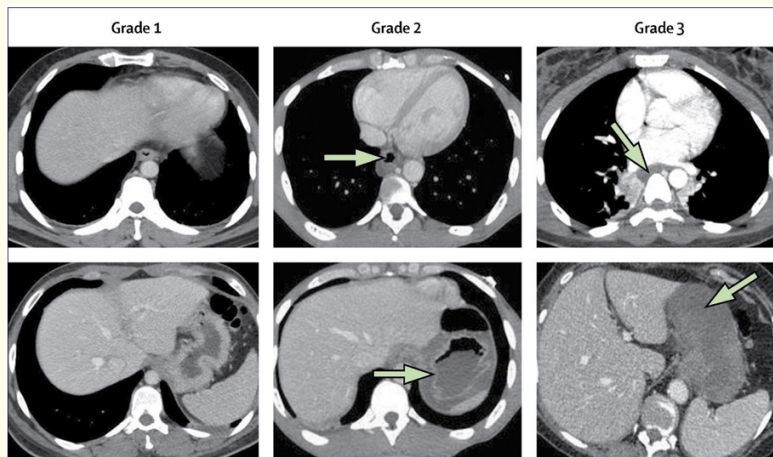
CT classification of esophageal and gastric injury after caustic ingestion [1].
